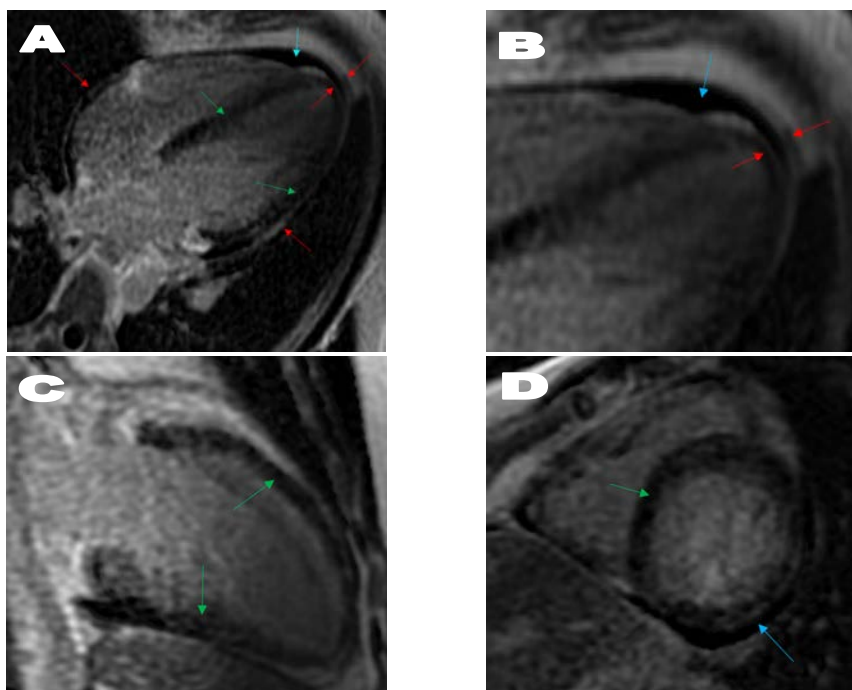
Cardiac magnetic resonance imaging, phase-sensitive inversion recovery (PSIR), four-chamber view (A, B), two-chamber view (C), short-axis view (D); to perform this sequence we choose inversion time to achieve appropriate nulling of the normal myocardium to accentuate late gadolinium enhance (LGE). Normal myocardium must be dark. In this case, that was not possible and we can conclude that LGE is diffuse heterogeneous transmural (green arrows). Pericardial effusion is hypointense on PSIR (blue arrows). LGE of thickened pericardium is hyperintense (red arrows).
